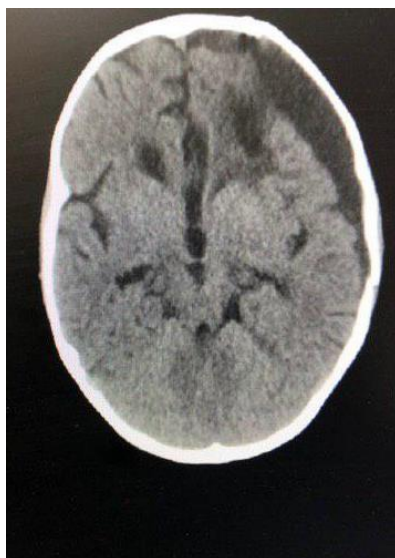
Follow- up CT- scan of the patient.
